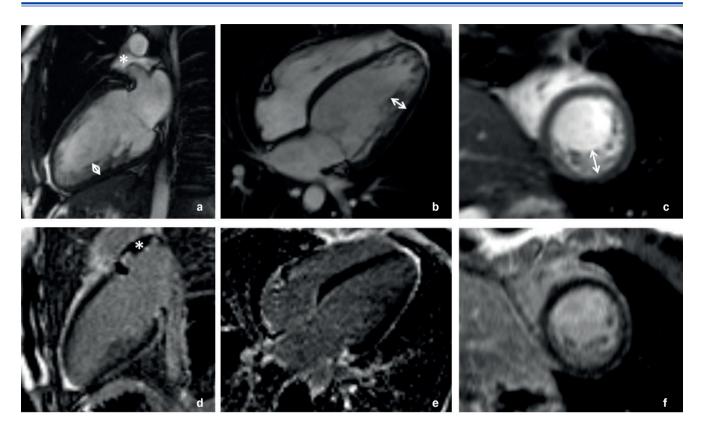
Cardiac MRI of the proband (II-2). ( $\mathbf{a}$ - $\mathbf{c}$ ) cine-mode, SSFP sequence:  $\mathbf{a}$  — long axis 2 chamber view,  $\mathbf{b}$  — long axis 4-chamber projection,  $\mathbf{c}$  — short axis, ( $\mathbf{d}$ - $\mathbf{f}$ ) — delayed contrast enhancement, IR sequence with suppression of myocardial signal. There are no areas of intramyocardial fibrosis, scarring and post-inflammatory lesions.
